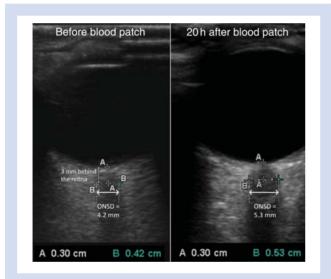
Example of ONSD measurement using sonography before and after EBP. The calliper is used to perform the measurement 3 mm behind the ocular globe (retina).
